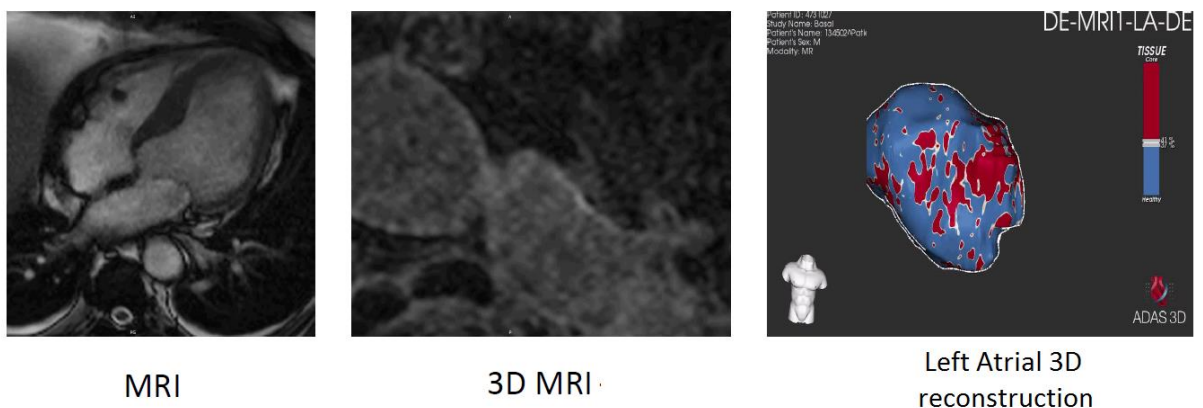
Left atrial 3D reconstruction from MRI.
